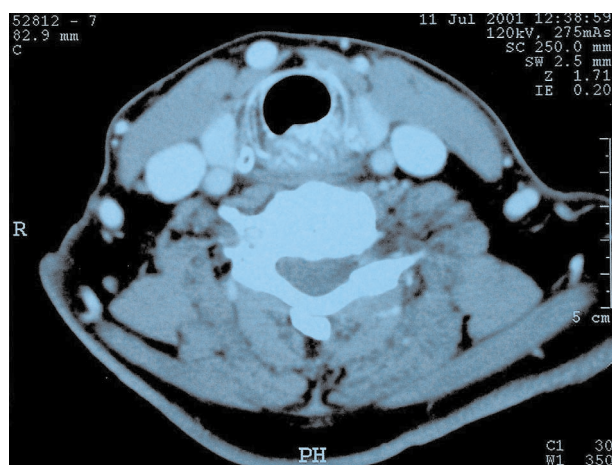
CT scan demonstrates infiltration of thyroid cartilage by tumor
